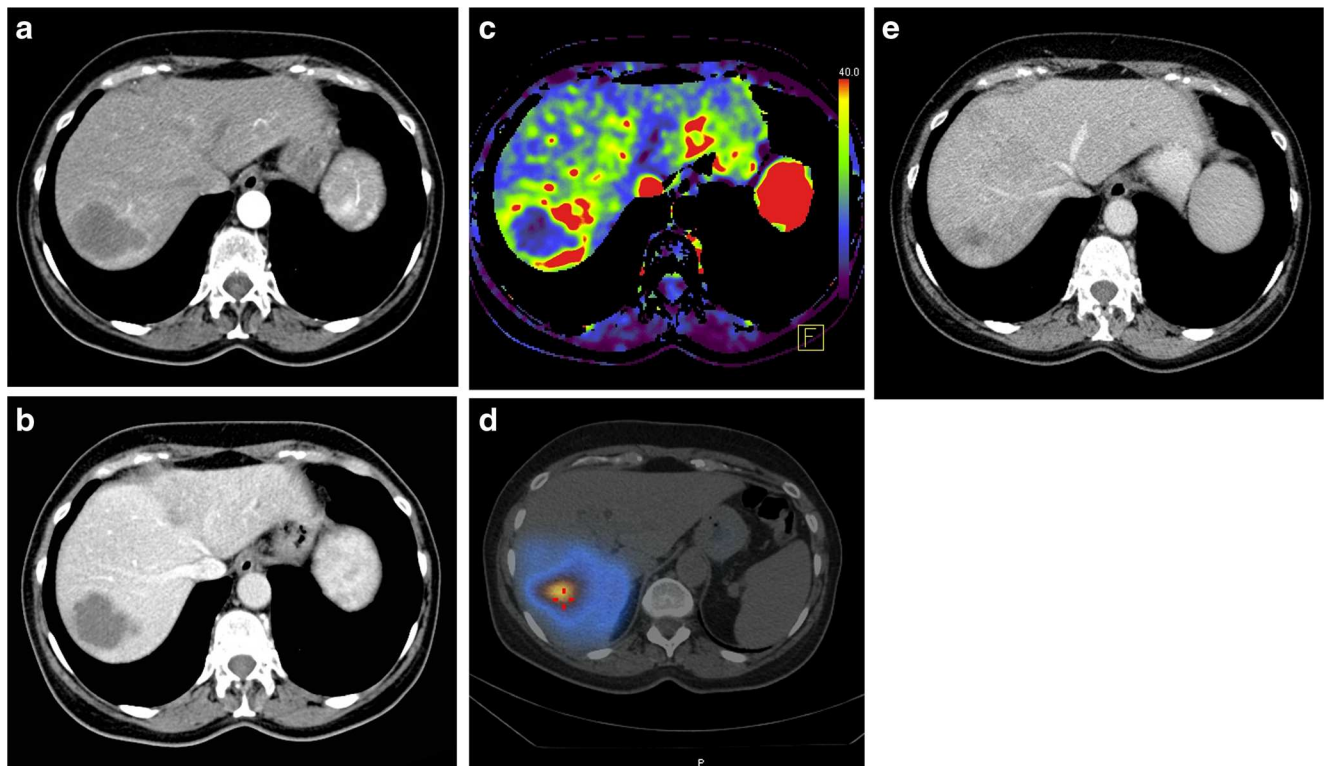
A 66-year-old female patient with metastases from colorectal cancer in the right liver lobe. The metastasis had an attenuation on portal venous phase CT (pvHU) of 71 HU (a) and on arterial phase CT (aHU) of 49 HU (b). The arterial perfusion of the metastasis was 25 ml/100 ml/min
